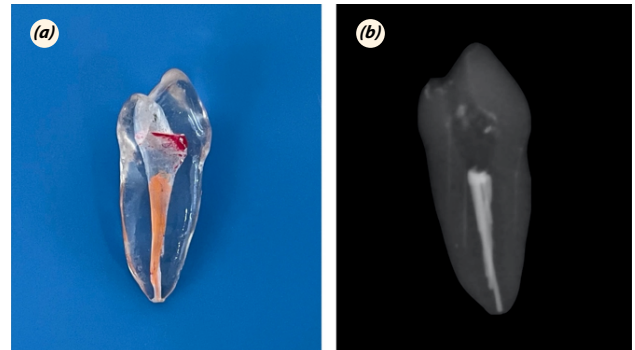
The figure represents the 3D printed mandibular premolar tooth model (a) and its radiographic image (b).
